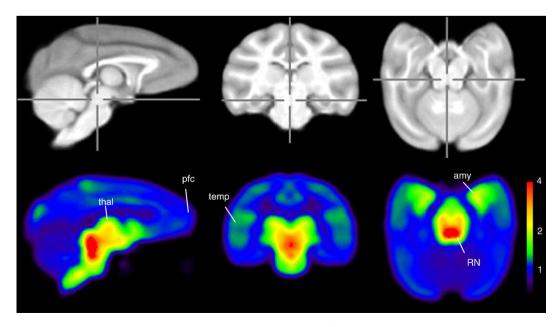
Binding of [C-11]DASB in the rhesus brain. The MRI image (top row) is coregistered to the [C-11]DASB DVR image (bottom row). Binding is highest in the raphe nucleus (RN) region of the midbrain, with elevated levels of binding also seen in the thalamus (thal), amygdala (amy), lateral temporal cortex (temp) and prefrontal cortex (pfc).
